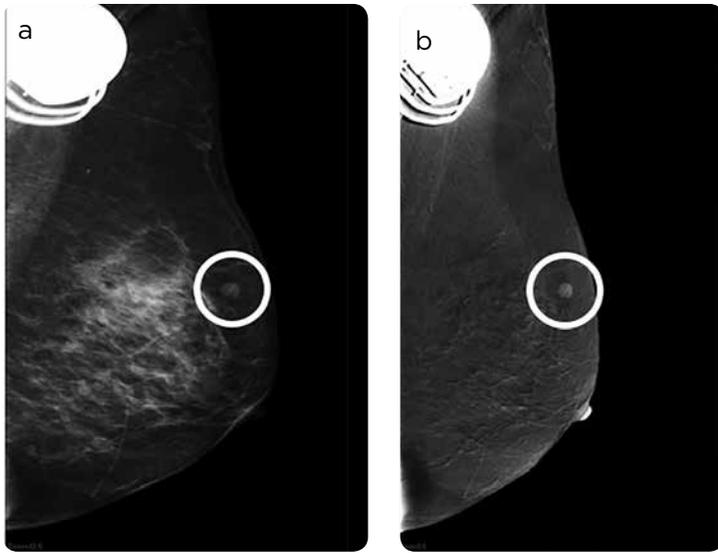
77-year-old patient referred to MR for study of focal asymmetry in left breast SEC. Pacemaker holder. In low energy projection (a) the area of asymmetry in left SEC is observed only seen in the oblique projection, which in the high-energy projection had a slight contrast enhancement and the ultrasound complement corresponds to an intramammary ganglion. BI-RADS 2 is assigned.
